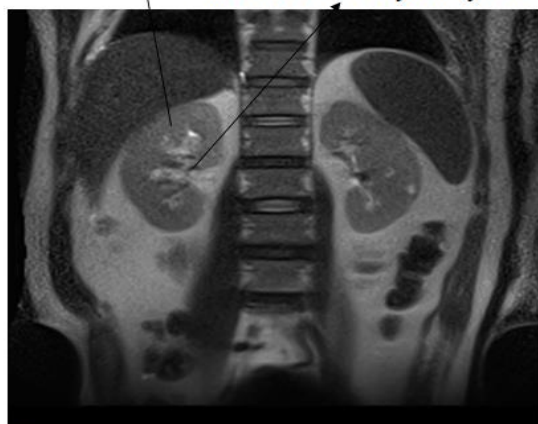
MRI scan shows a well circumscribed, 31mm diameter, lesion is identified along the supero-posterior cortical pole of the right kidney. It extends deep towards the calyceal system.
